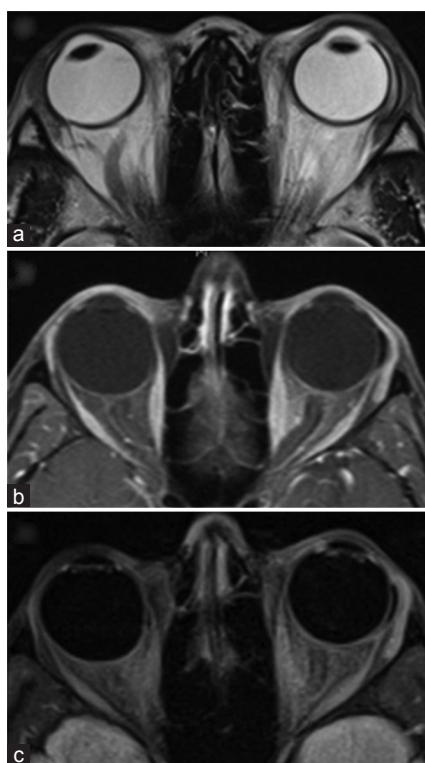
Typical appearance of GDI and lacrimal gland on various imaging modalities. (a) Axial T2 MRI of the brain of a 45-year-old woman with left superotemporal AGV for chronic angle-closure glaucoma (40 months after GDI). The GDI appears as a dark curvilinear structure, with bright linear signals representing bleb fluid on the deep and superficial surfaces of the device plate. The lacrimal gland is flattened and posteriorized compared to the unoperated side. (b) Axial T1 fat-saturated sequence of a 56-year-old woman with a left BGI for uveitic glaucoma (15 months after GDI). A thin bright line of the bleb fluid is collected over the dark curvilinear device plate. There are also commonly seen intermediate density soft tissue changes surrounding the GDI surface, as well as flattening and posteriorization of the lacrimal gland. (c) Same patient in B, T2 FLAIR sequence.
